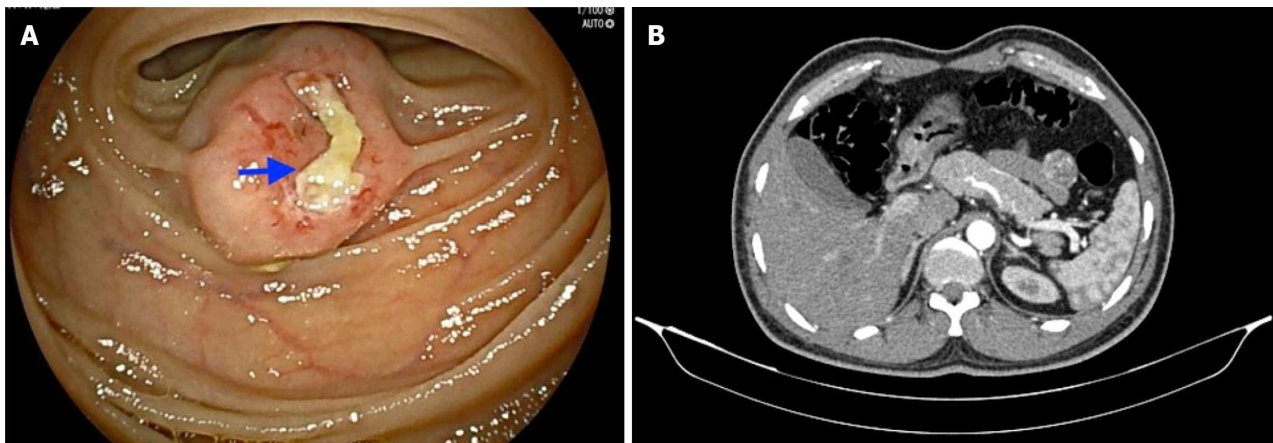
Imaging examinations. A: Double-balloon enteroscopy image showing a subepithelial lesion (2 cm × 1.5 cm) approximately 150 cm distal to the duodenojejunal flexure and an overlying ulcer without any active bleeding; B: A contrast-enhanced computed tomography abdomen scan revealing a well-defined, round-shaped, homogeneously enhancing solid exophytic lesion (30 mm × 22 mm × 26 mm) arising from the proximal jejunal loops without any obvious adjacent organ involvement, internal necrotic foci or calcification.
